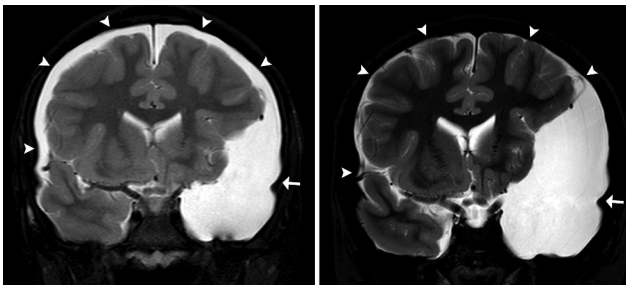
Neuro-imaging assessment. The left image shows T2-weighted coronal magnetic resonance imaging (MRI) at presentation, showing the arachnoid cyst in the left middle cranial fossa (white arrow), associated with a large subdural hygroma extending to the contralateral hemisphere (white arrowheads). On the right, subsequent T2-weighted coronal MRI after 1 year of follow-up showing a robust decrease of the subdural fluid collection (white arrowheads).
